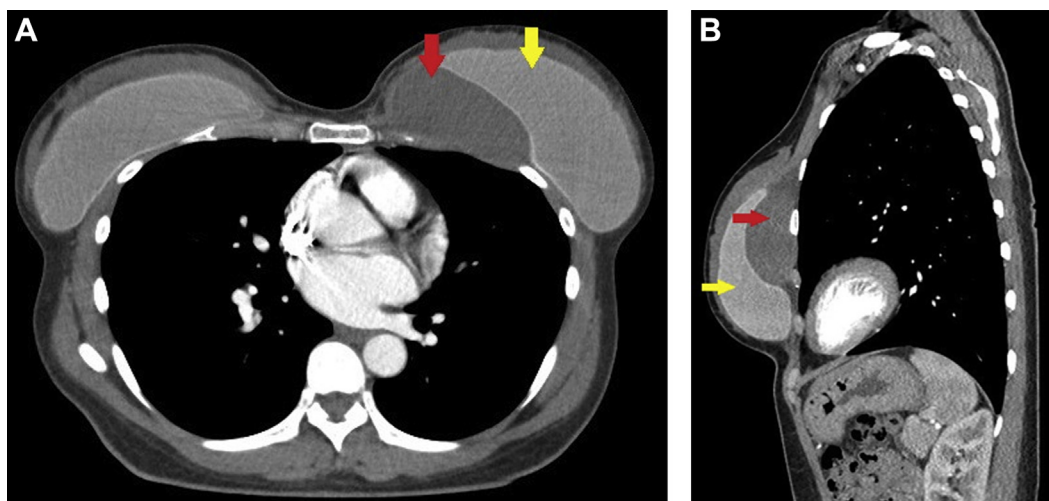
(A) Axial and (B) sagittal images of a contrast-enhanced CT of the chest reveals a 3.5 cm × 7.7 cm × 7.3 cm hypoattenuating lesion (red arrow) deep and medial to the left breast implant (yellow arrow).
